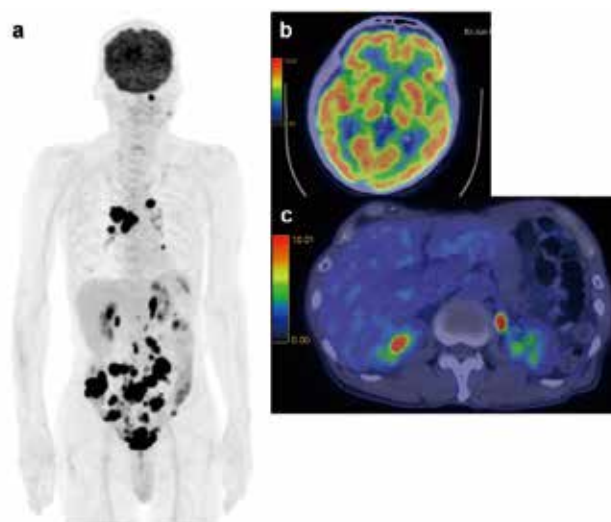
FDG PET/CT images of representative case showing brain and liver uptake decrease with high tumor uptake. The tumor was diffuse large B-cell lymphoma (DLBCL). Maximum intensity projection of FDG PET (a), PET/CT fusion image of brain (b), PET/CT fusion image of liver (c) of a 70-year-old male. Each parameter follows ; SUV_{max} of 2.9, SUV_{mean} of 2.2 in liver, SUV_{max} of 11.4, TGV of 6958.0 in brain, SUV_{max} of 31.3, TLG of 3450.4, MTV of 329.6 in DLBCL lesions.
